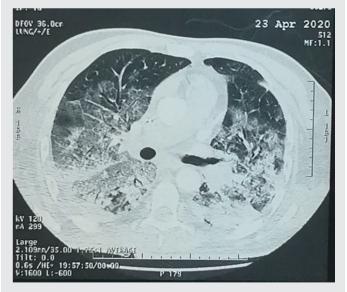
Thoracic CT scan with extension of ground glass areas with posterior and basal condensations.
